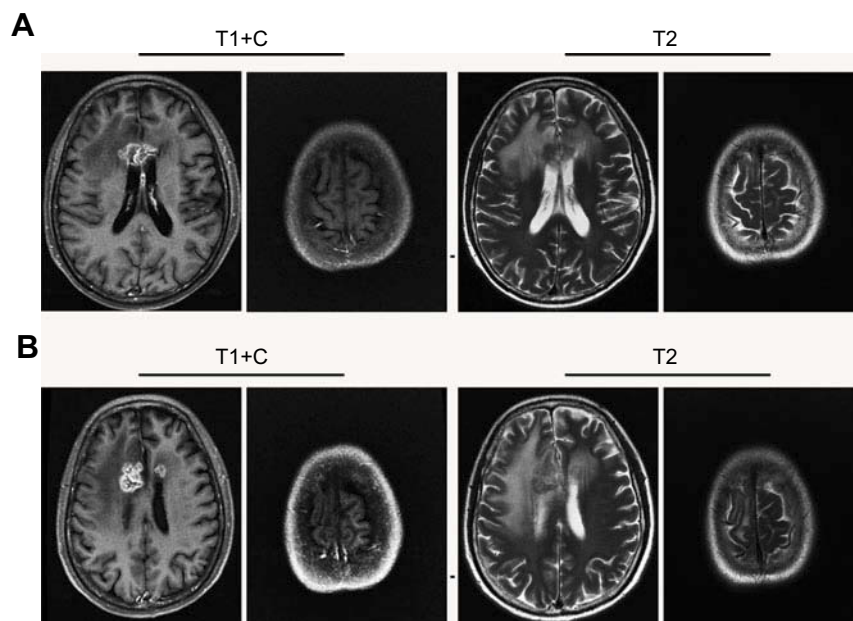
MRI detection of brain metastasis recurrence and MRI scanning after administration of the temozolomide regimen. (A) An MRI scan revealed an irregularly strengthened signal in the anterior corpus callosum and peripheral edema of the lesions. (B) One year after administration of the temozolomide regimen for four cycles, an MRI scan revealed that the lesions in the anterior corpus callosum had decreased, but the size of the lesions in the right lateral ventricle had significantly increased.
